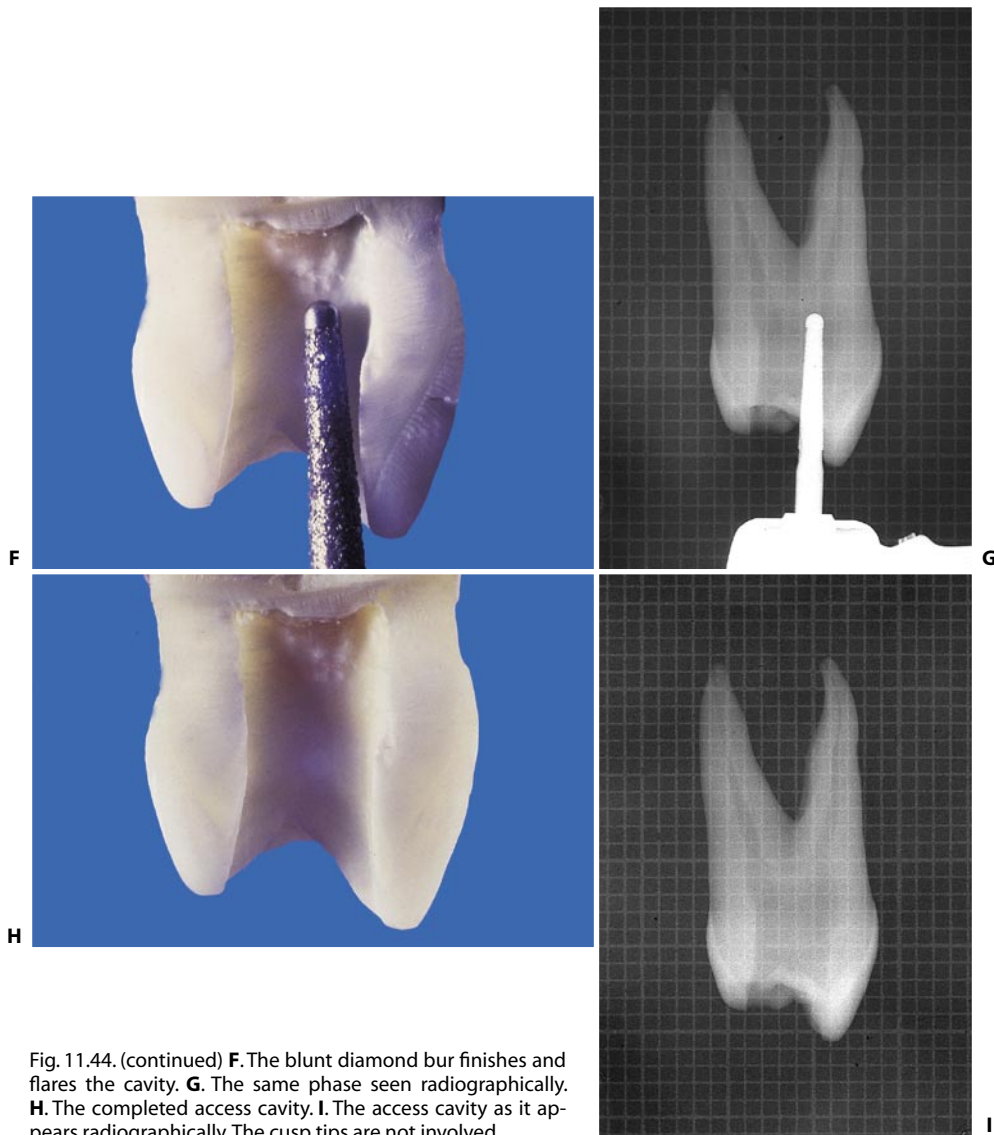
(continued) F. The blunt diamond bur finishes and flares the cavity. G. The same phase seen radiographically. H. The completed access cavity. I. The access cavity as it appears radiographically. The cusp tips are not involved.
